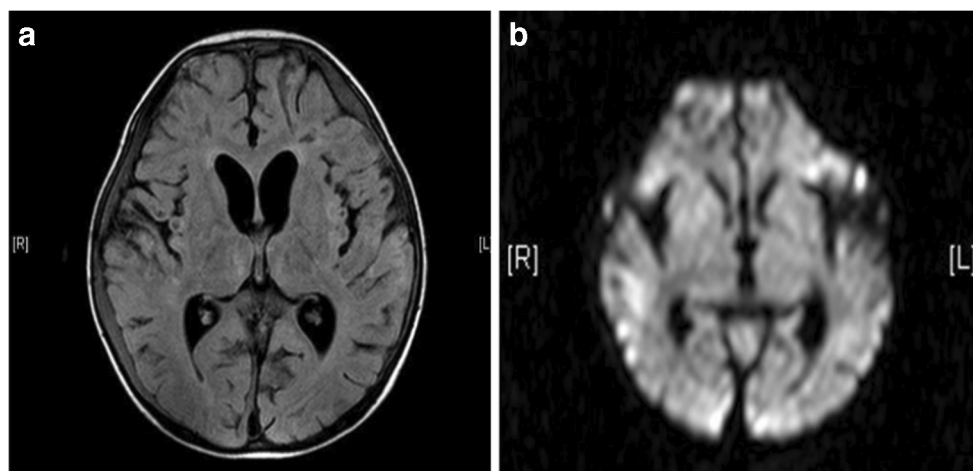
Brain magnetic resonance imaging (MRI) on day 4 after admission revealed multiple asymmetrical patchy areas of hyperintensity on T2-weighted fluid-attenuated inversion recovery (T2-FLAIR) images, in both white and gray matter in bilateral hemispheres, bilateral lentiform nuclei, thalami, hypothalami, corpus callosum, and brainstem (white
